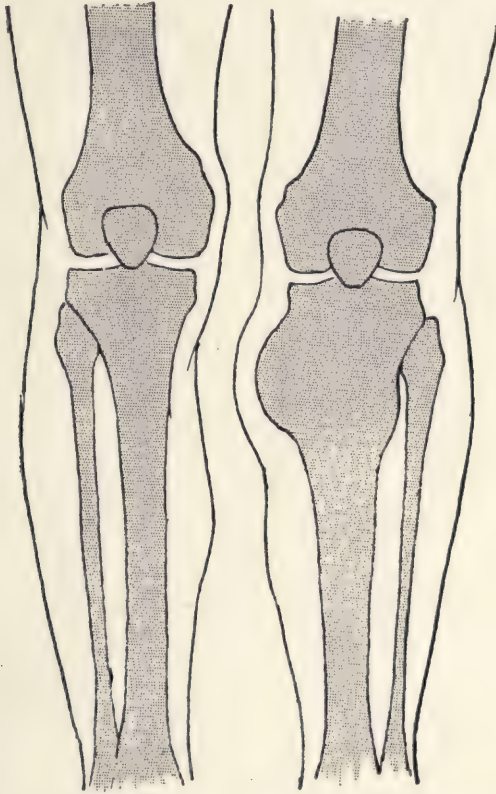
Osteo-sarcoma of the tibia (from a radiograph). Diagnosis from osteomyelitis. In osteo-sarcoma the bone is like a club, it is fusiform in osteomyelitis (see fig. 1030). In osteo-sarcoma the onset is insidious, there is scarcely ever fever, development less rapid.
